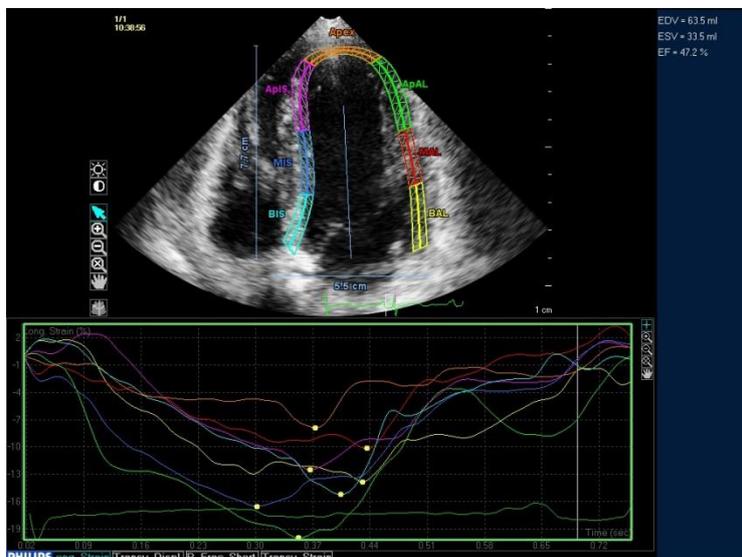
Apical 4 chamber (AP4C) view showing speckle tracking. Longitudinal segments are divided into segments by an automated algorithm. Each coloured wave below represents the strain of one segment tracked. The Y-axis is a percentage of lengthening and is from 0 to -20. The X-axis is time in seconds.
